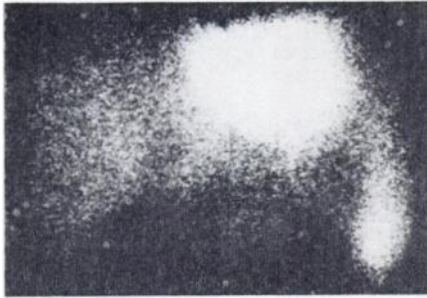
Anterior scintigram of liver in Case 5 with BCS shows "heart-shaped" area of relatively increased uptake in midline and left lobe region.
